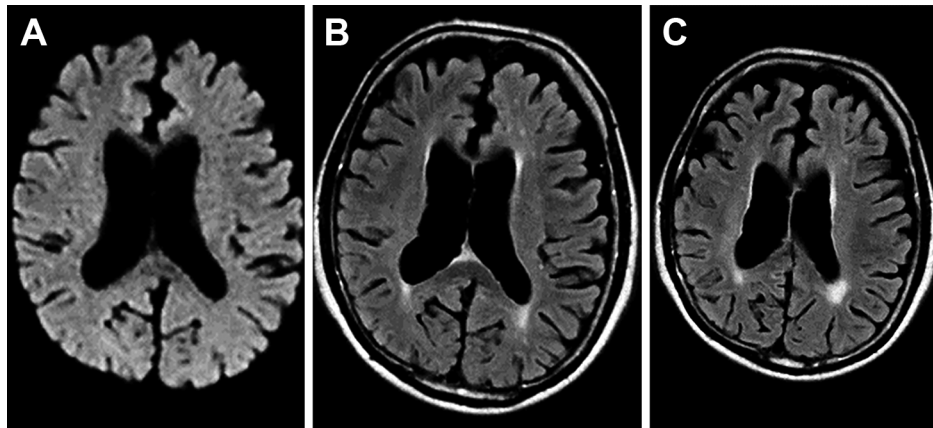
Axial view of brain MRI on day 1 after admission.
